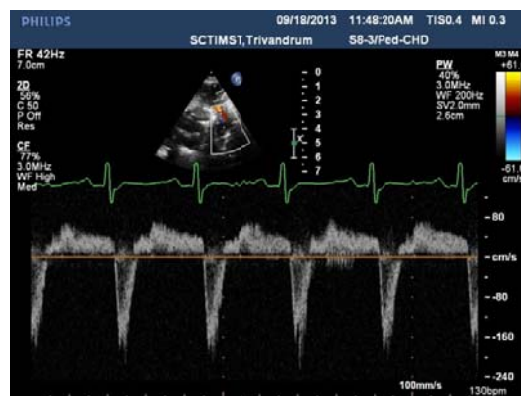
Pulse wave Doppler with diastolic flow reversal in descending aorta.
